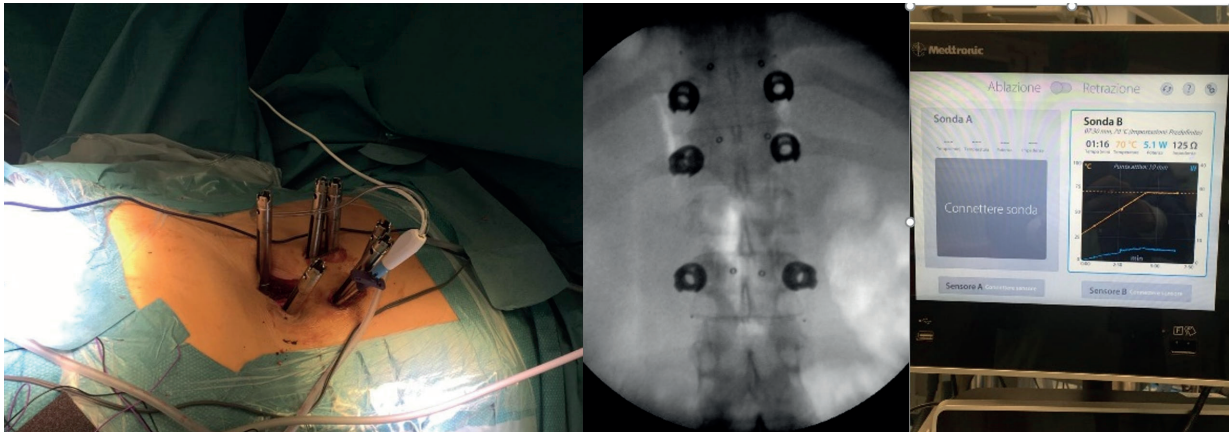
Intra-operative images showing surgical approach, intraoperative X-rays and thermal ablation management of the case in Figure 6.
